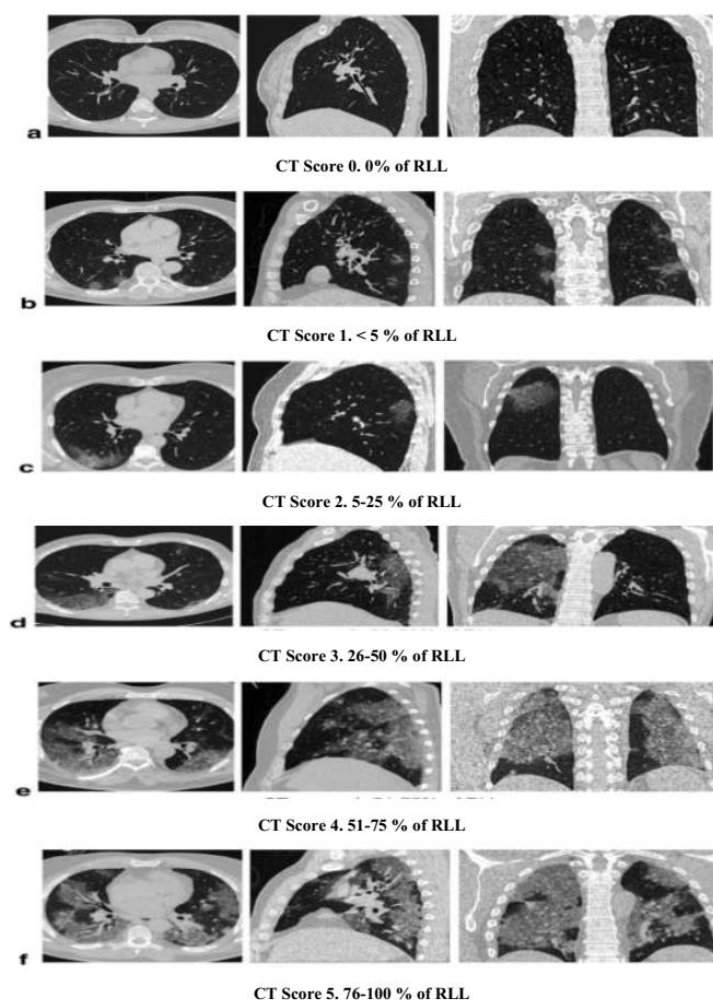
Different CT score of RLL involvement in COVID-19 pneumonia on axial, sagittal, and coronal images. 0% of RLL lobe involvement (a); <5% of RLL involvement (b); 20% of RLL involvement (c); 40% of RLL lobe involvement (d); 70% of RLL involvement (e); >75% of RLL involvement (f)
